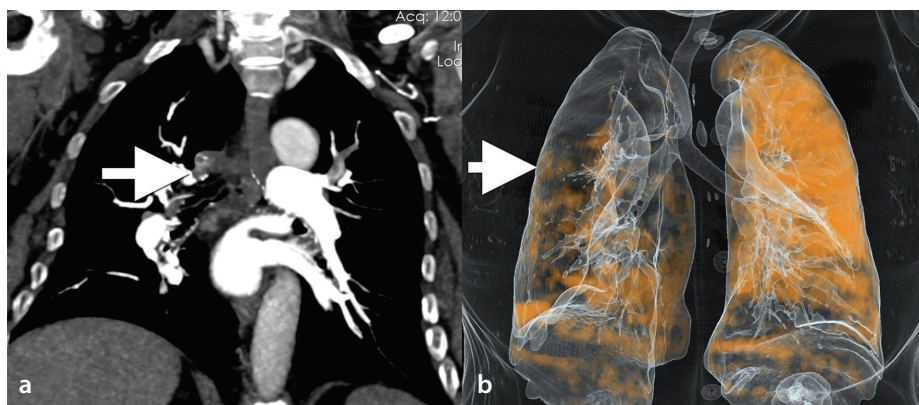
Coronal reformatted dual-energy computed tomography pulmonary angiography and volume-rendered perfusion images. (a) Lobar occlusion of the right upper lobe pulmonary artery due to chronic thromboembolic pulmonary hypertension (arrow); (b) corresponding three-dimensional volume-rendered perfusion image reveals marked perfusion defects in the right lung (arrow).
